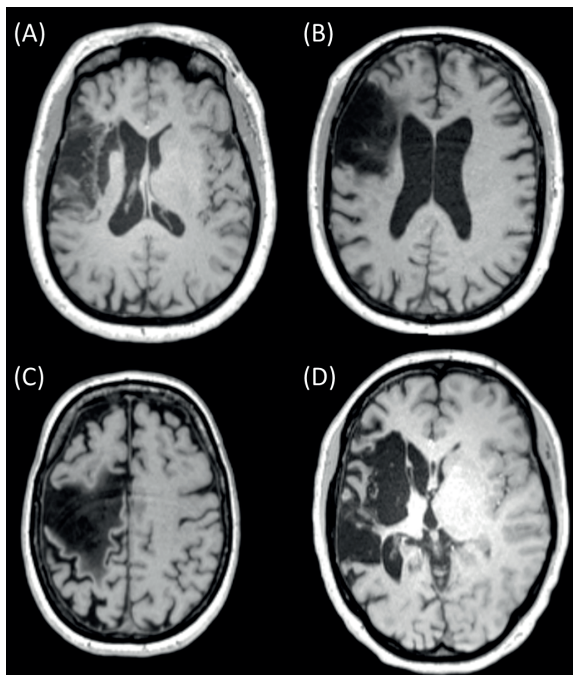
MRI slices of 4 different chronic stroke subjects showing lesions of various sizes and mixed composition (A (subject 042), B (subject 034) and C (subject 051)) and with primarily CSF (D (subject 055)). Ethical approval was acquired to record and publish the MRI slices with consent from the participants (see NL58437.091.17).
